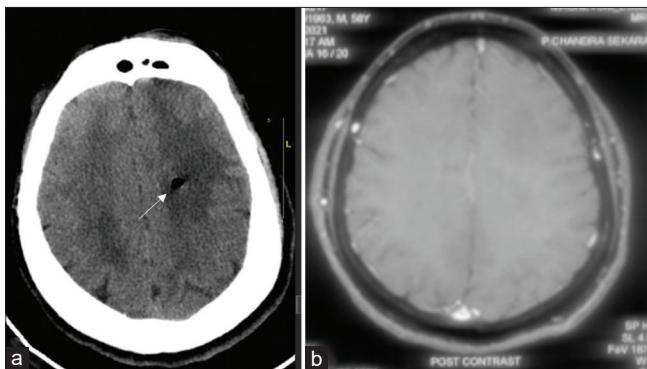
(a) Post procedure plain computed tomography showing mass effect and perilesional edema as an indirect evidence at corresponding cuts with white arrow indicating biopsy site. (b) In an index case of left diffuse hemispheric glioma preoperative contrast magnetic resonance imaging sequence.
